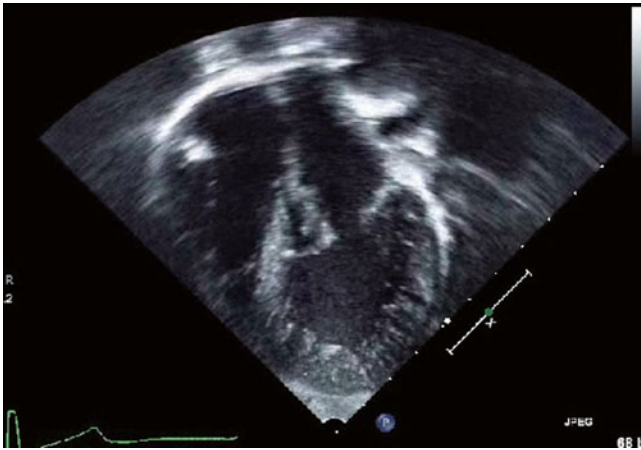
Representative echocardiogram in LVNC. Deep recesses and trabeculations are seen in the apex of this heart
